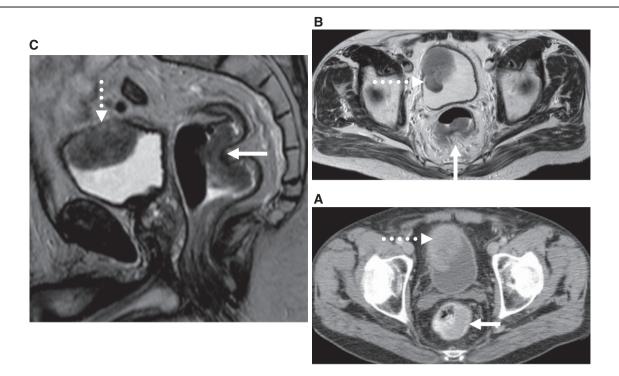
Synchronous bladder and rectal carcinoma. (a) CT, (b) axial and (c) sagittal T2-weighted MR images in a man who presented with haematuria and diarrhoea and was found to have synchronous small cell bladder (dotted arrow) cancer and rectal adenocarcinoma (arrow) confirmed at pathology.
